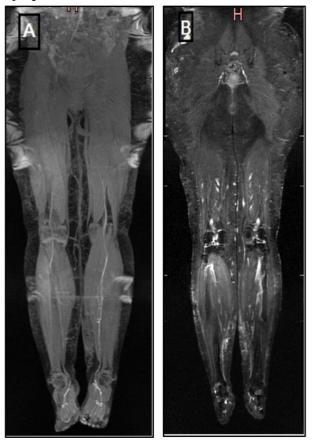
(A) Coronal MRI post-contrast T1 fat suppression shows flow lymphatics are depicted within the dermal backflow assuming faint honeycombing appearance at left side. (B) Coronal STIR MRI shows bilateral asymmetrical medial legs subcutaneous edema more prominent at left side.
